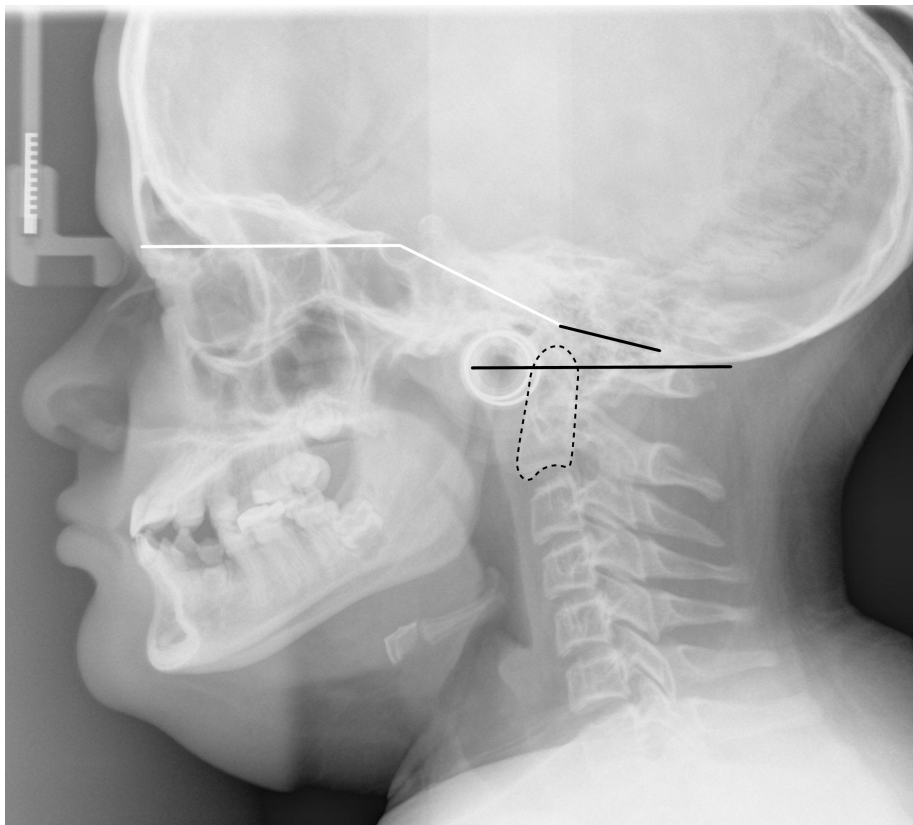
Radiograph of a female aged 13.5 years with type III OI exhibiting basilar impression and platybasia in the absence of basilar invagination. McRae's line and D-M distance line are indicated in black, and the anterior cranial base angle in white.*
